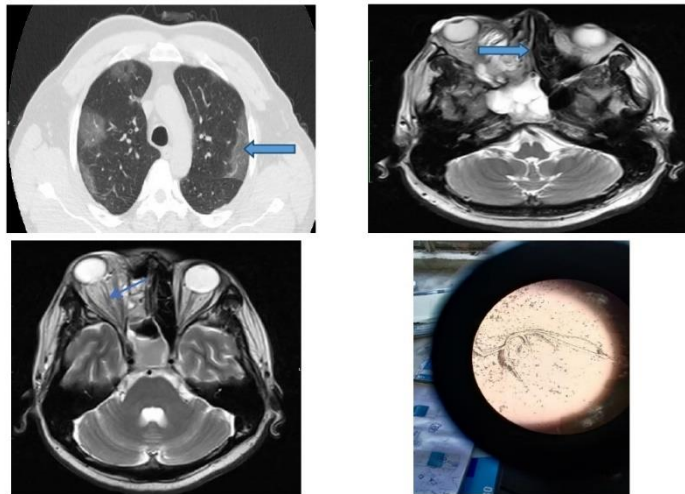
A 50 Years male patient CT Chest shows bilateral diffuse GGO, MRI: mucosal thickening with T2 hypointensity noted within the right maxillary sinus, ethmoidal sinus, nasal cavity and bilateral sphenoid sinuses. Minimal mucosal thickening noted in the right frontal sinus. Right orbit: intra and extraconal fat stranding noted. Medial rectus, inferior rectus and superior oblique muscles appears bulky. Minimal collection noted along the medial wall of right orbit. Preseptal edema of the right eyeball with pre-septal edema. KOH Mount: Shows fungal elements.
